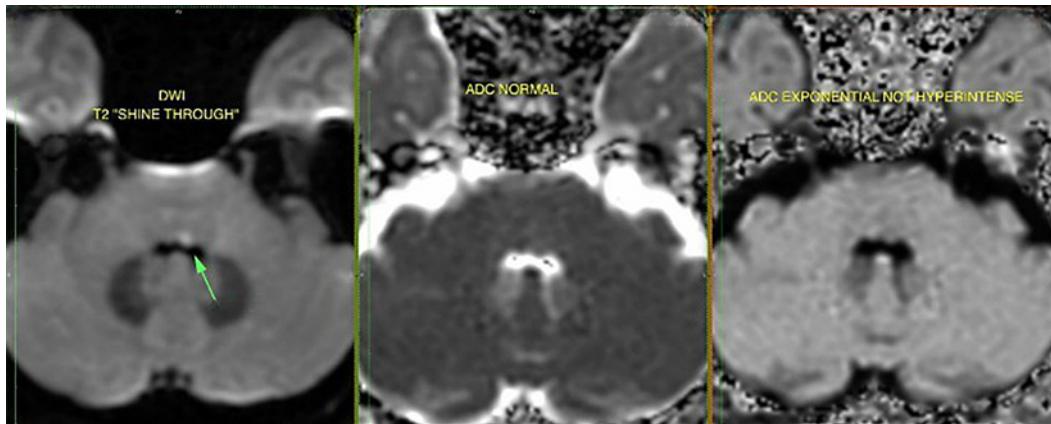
Brain MRI findings rule out acute ischemia. Hyperintensity on diffusion-weighted imaging caused by T2 shine through supported by normal ADC and ADC exponential not hyperintense.
